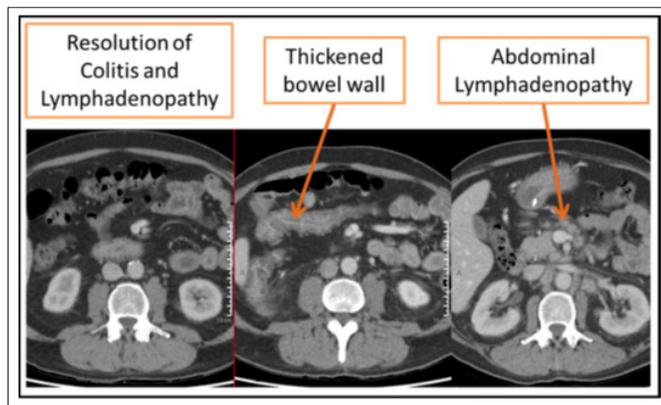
CT Scans showing Lymphadenopathy prior to commencing Nivolumab, Colitis following 3 cycles of Nivolumab given fortnightly and resolution of both in most up to date scan.
